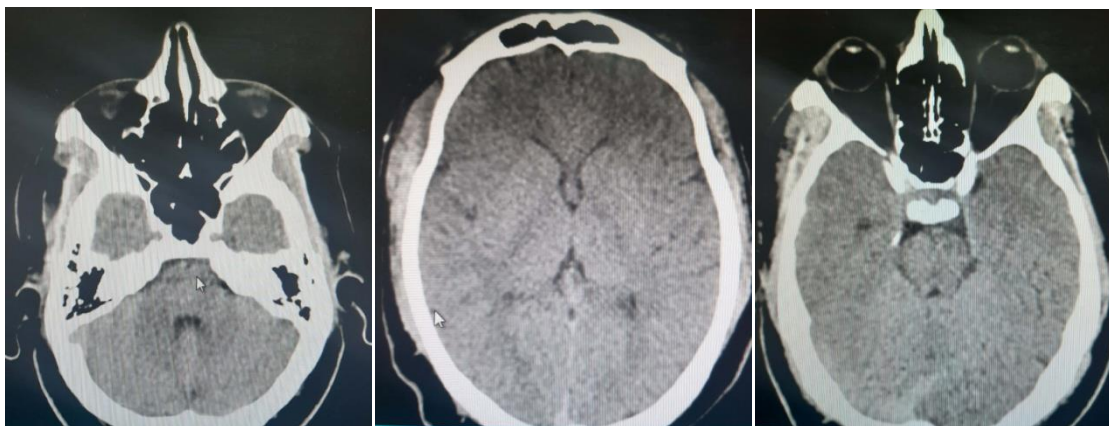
CT brain showing no obvious abnormality
